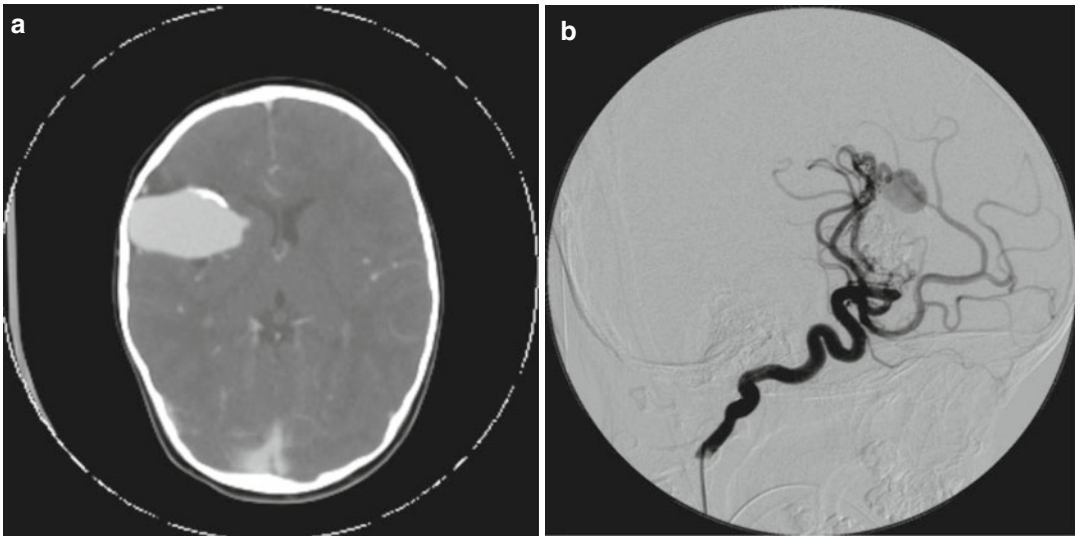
(a) Computed tomography scan and (b) angiogram of a saccular aneurysm
